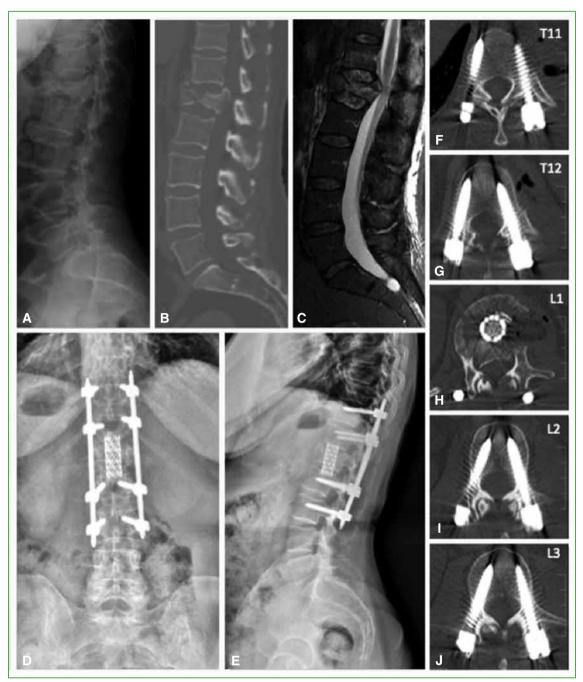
Patient 6. 60 year-old woman who suffers a motor vehicle collision. A. Profile radiography of the lumbosacral column, B. Computerized tomography, sagittal planes, C. MRI T2 sequence. An AO A4 fracture of the first lumbar vertebra is confirmed. The vertebral body has collapsed, compromising the posterior wall. There is a 15° segmental kyphosis, and the vertebral height is 15 mm. Four days after admission, she undergoes a percutaneous stabilization from T11 to L3 (D and E). In a second surgical time, with the patient being clinically stable, a lateral minimally invasive arthrodesis is performed from T12 to L2, using a mesh cage and an autologous crest and rib bone graft. F-J. Follow-up computerized tomography, after 36 months. There can be observed the position of the pedicle screws (5 in 1A and 3 in 1B, according to Zdichavsky).
